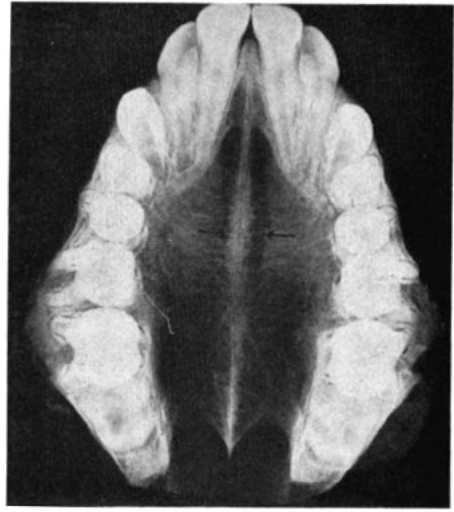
Occlusal radiograph showing improvement of midline region.
